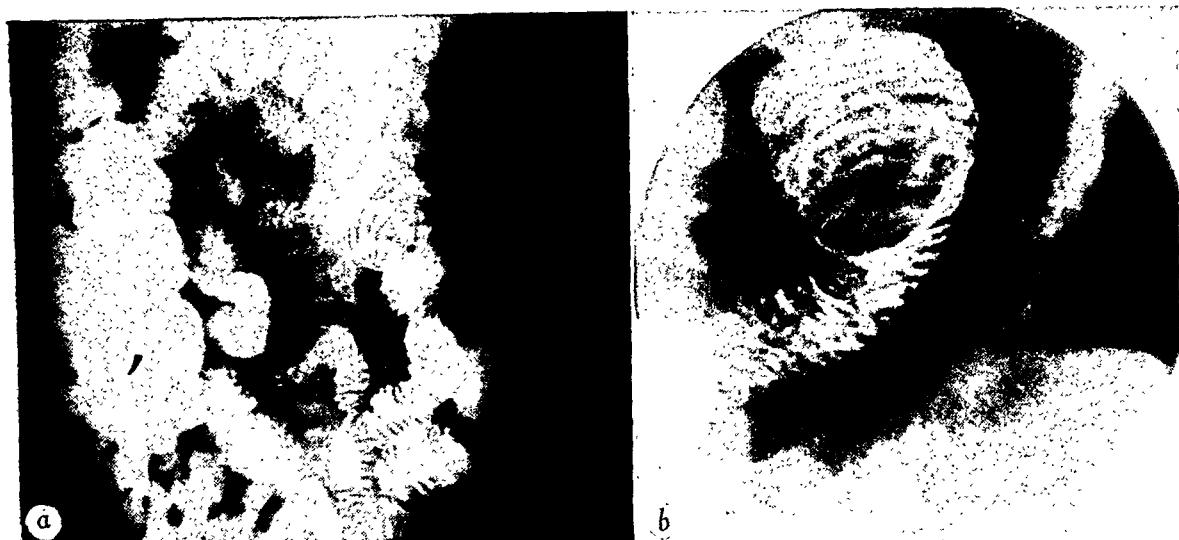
Case 3: *a*. Enter-enteric intussusception caused by leiomyosarcoma; the "concentric ring" appearance and the difference in diameter between the involved and uninvolved jejunum are characteristic. *b*. "Spot" radiograph of the lesion.
